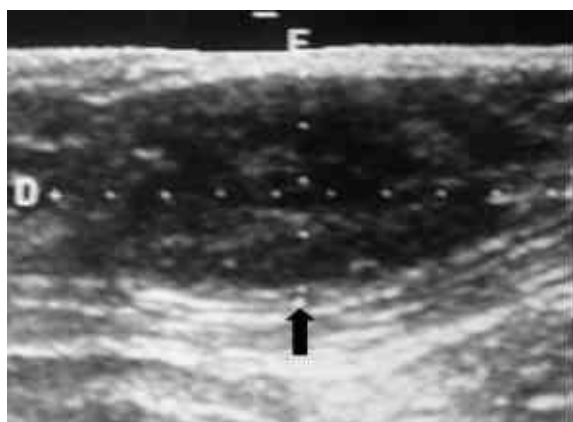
An ultrasound examination showing subcutaneous hypo-echoic mass, 3.0 x 2.9 cm in size (black arrow) due to the administration of leuporelin acetate 11.25 mg.
